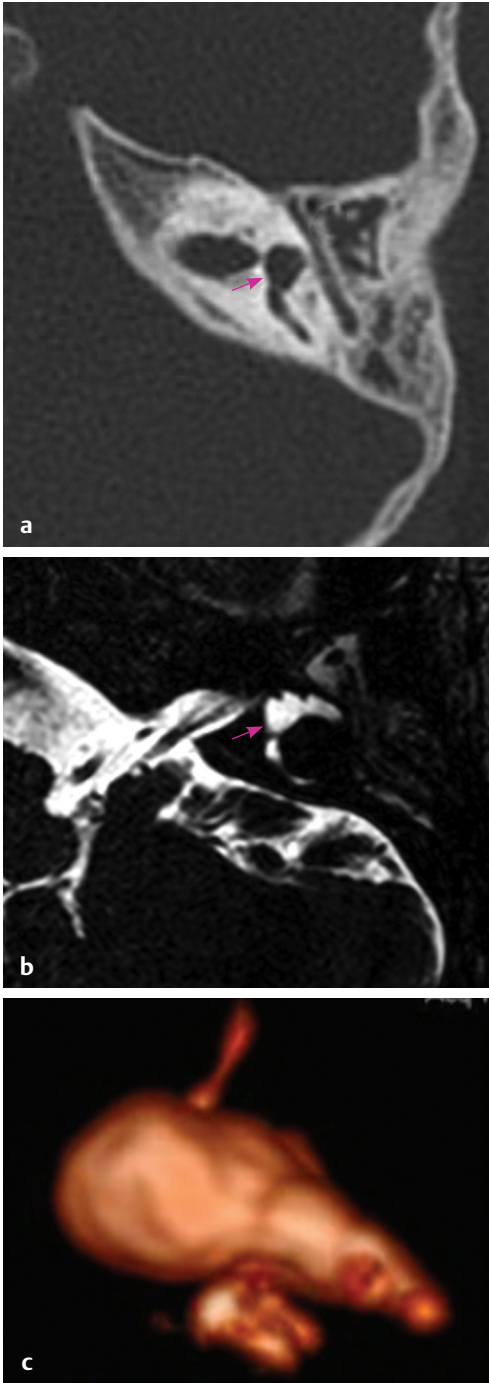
(a) HRCT temporal bone, bone window and (b) MRI CISS sequence, axial section shows normal vestibule (pink arrow) and absent cochlea (c) 3D reconstructed image showing cochlear aplasia.
